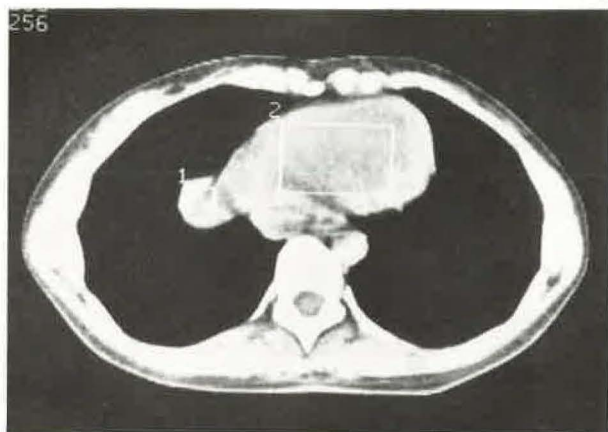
CT image. Density in the lesion (area 1) is 16 HU, while the heart (area 2) shows a density of 45 HU. CT computerized tomography.
